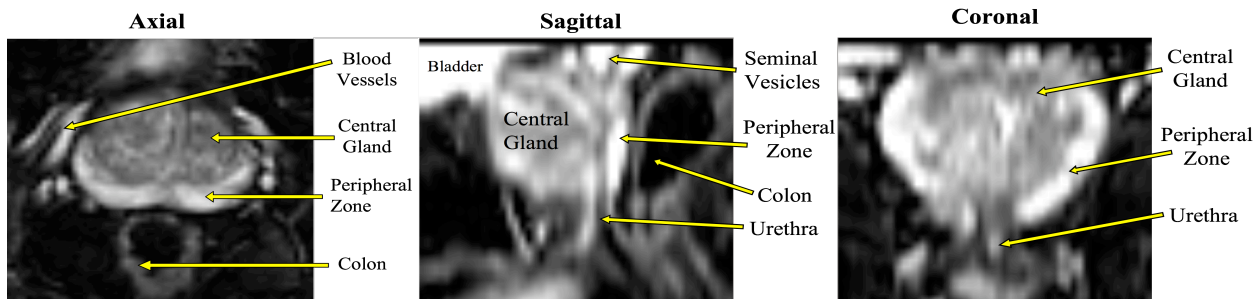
The appearance of the prostate in T2 weighted Fat suppressed MRI sliced in three orthogonal planes.
